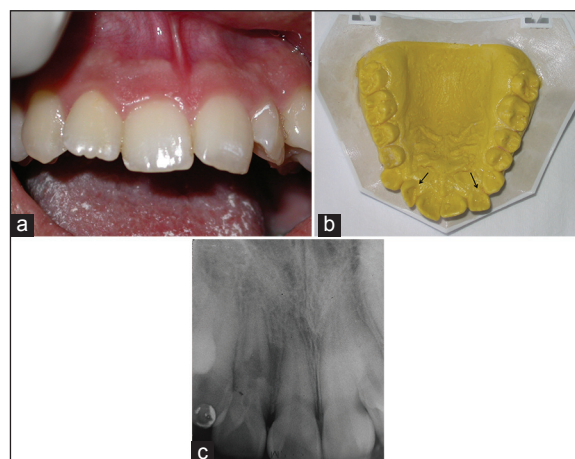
(a) Clinical appearance of the tooth before treatment. (b) The appearance of the stone model of the patient. Dens invaginatus is seen in cingulum region of maxillary lateral incisors (arrows). (c) Periapical radiography of the tooth
